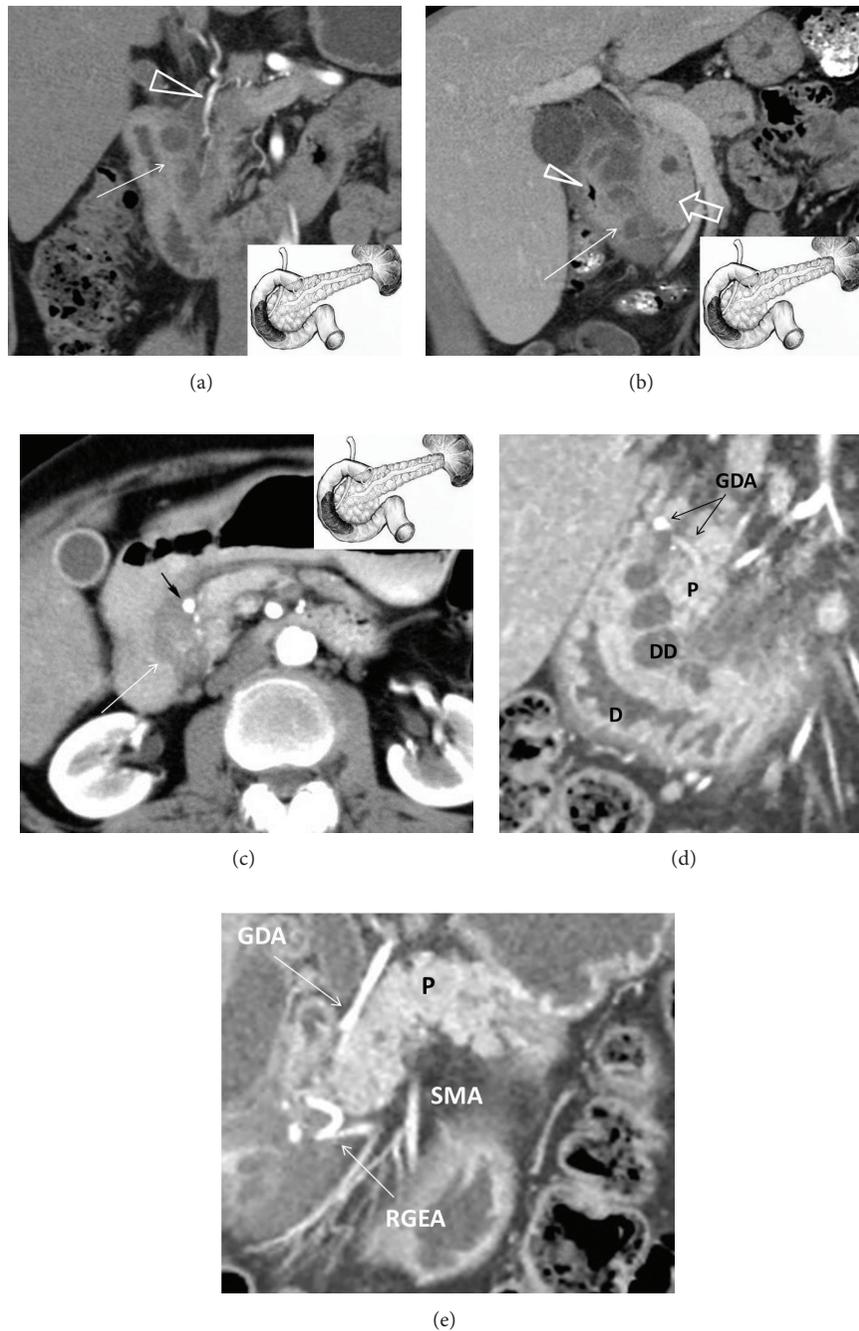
Duodenal dystrophy with moderate chronic orthotopic pancreatitis. Multidetector computed tomography. Frontal view. Patient, 32 y.o. (a) Arterial phase. Deformation and thickening of the medial wall of the duodenum with septated cyst (arrow). The gastroduodenal artery is shifted forward and to the left, lying in the groove between the pancreatic head and affected duodenal wall (arrowhead). The scheme of the lesion and the unaffected main pancreas is in the lower right corner; (b) patient 44 y.o. Venous phase. Deformed and thickened medial duodenal wall with multiple cysts (arrow), separated from moderately changed pancreatic head (thick arrow), is narrowing the duodenal lumen (arrowhead). The scheme of the lesion and the unaffected main pancreas is in the lower right corner; (c) patient 49 y.o. Arterial phase. Deformation and thickening of the medial wall of the duodenum with contrasted pancreatic tissue inside (arrow). The gastroduodenal artery is shifted forward and to the left, lying in the groove between the pancreatic head and affected duodenal wall (black arrow). The scheme of the lesion and the unaffected main pancreas is in the upper right corner. (d) Isolated form of the duodenal dystrophy. Multidetector computed tomography. (d) Male, 57 y.o. Arterial phase. Sagittal view. Deformation and thickening of the medial wall of the duodenum (D) with septated cysts (DD). The gastroduodenal artery (GDA) is shifted forward and to the left, lying in the groove between the unaffected pancreatic head (P) and duodenal wall. (e) Isolated form of the duodenal dystrophy with unchanged orthotopic pancreas. (a) Male 57 y.o. Arterial phase. Sagittal view. Septated cysts in the submucosa and muscularis of the diffusely thickened duodenal wall surround the major papilla.
